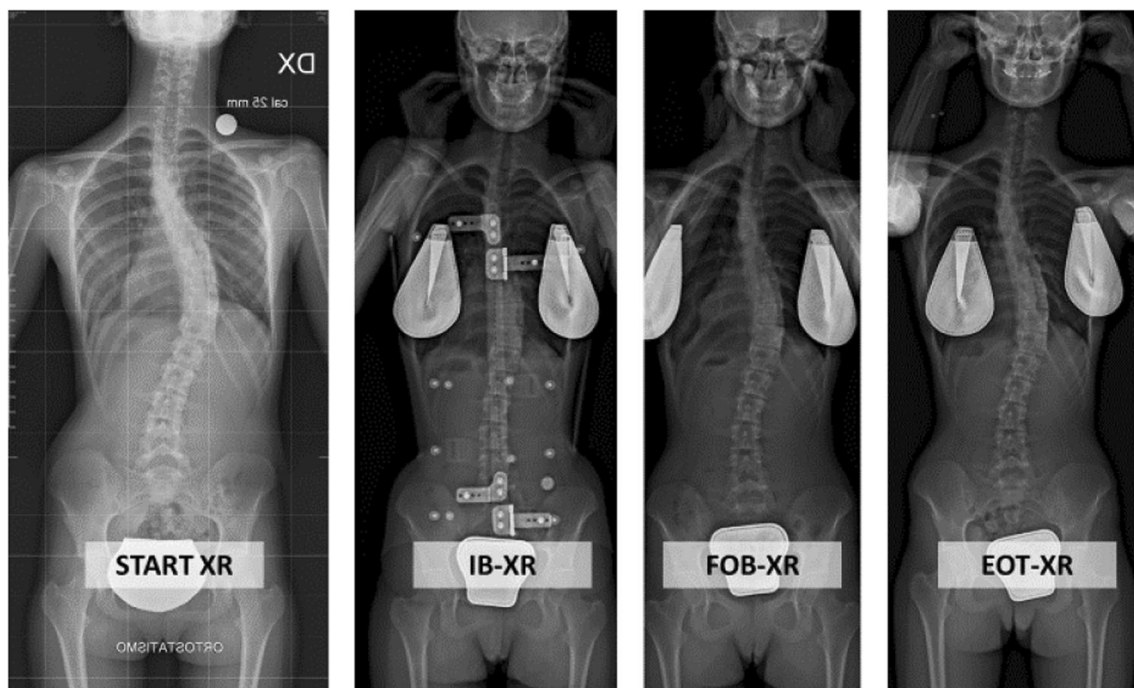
Example of radiographic protocol of one patient with a right thoracic curve starting at 54° and improving to 28° in-brace, 33° in the first out-of-brace radiograph and 36° at the end of treatment
